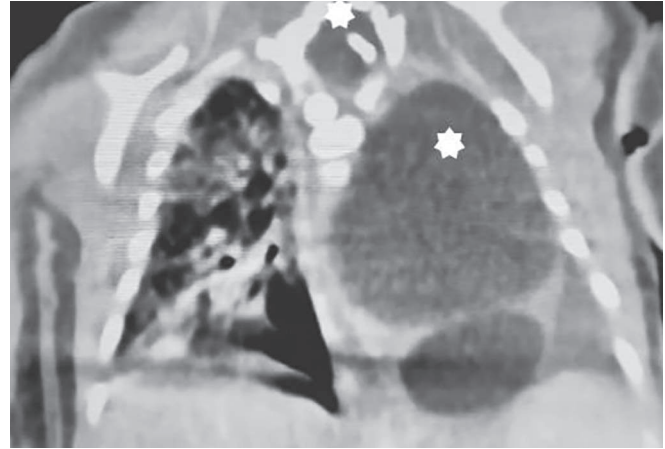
Contrast-enhanced chest CT scan showed a voluminous cystic tumor in the left pleural space containing liquid density with a significant mass effect on the left lung as well as the mediastinum. In the bone window, vertebral and costal fusion anomalies were observed affecting the T2 and T3 vertebral bodies
